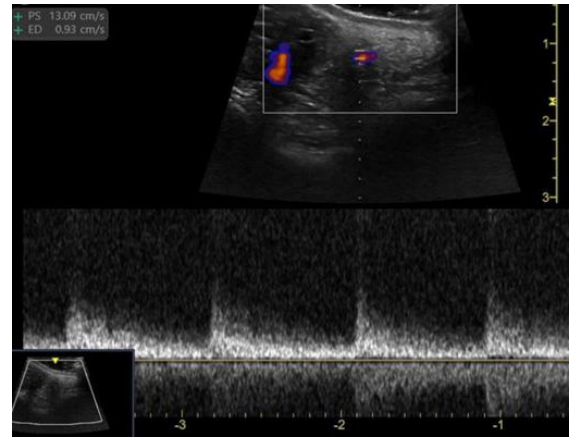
The spectral curve with Doppler analysis, Duplex color confirms the classic triphasic pattern of the facial artery
